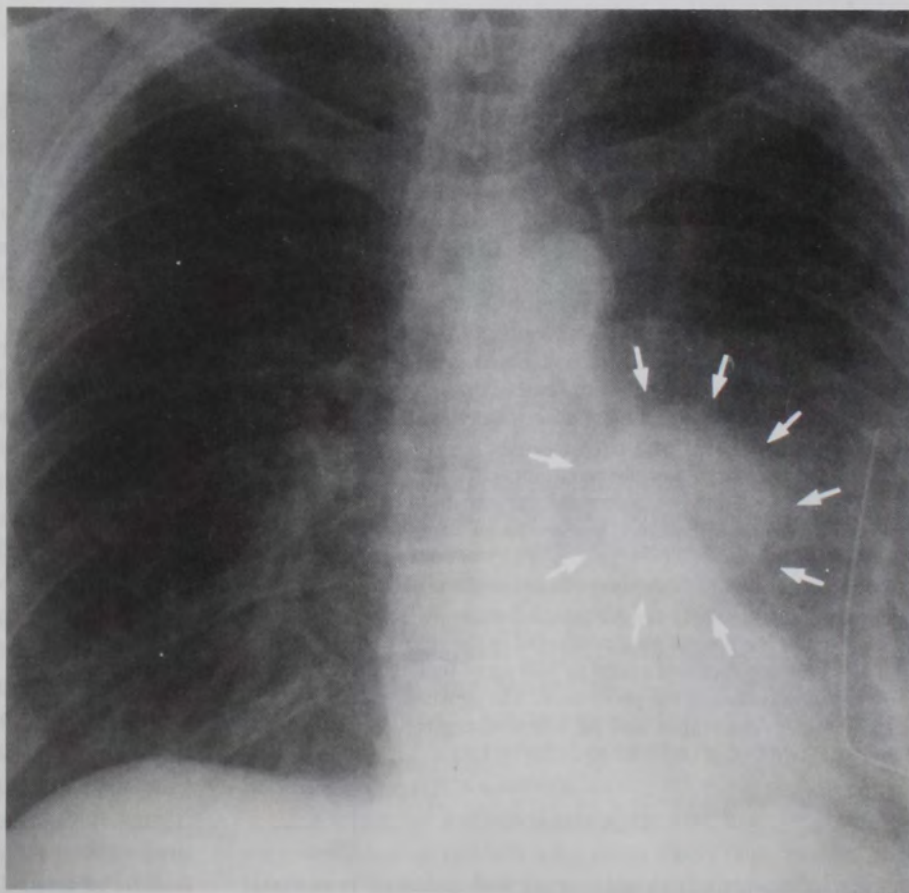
Chest roentgenogram revealing a discrete left perihilar mass consistent with a pulmonary artery pseudoaneurysm or arteriovenous fistula. The arrows outline the mass.
